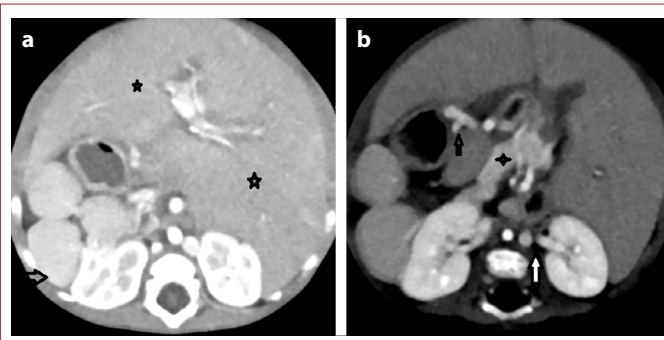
Contrast-enhanced abdominal CT images. (a) The liver is located in the midline, and both lobes exhibit a left-lobe configuration (asterisks). Multiple splenules consistent with polysplenia are seen (arrow). (b) A right-sided stomach, a preduodenal portal vein (black arrow), a shortened pancreas (asterisk), and a dilated azygos vein (white arrow) are observed.
